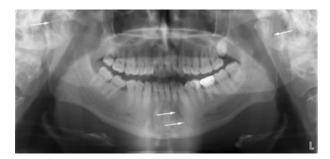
Panoramic radiograph showed the fracture in the left mandibular incisor region and bilateral condyle fractures.
